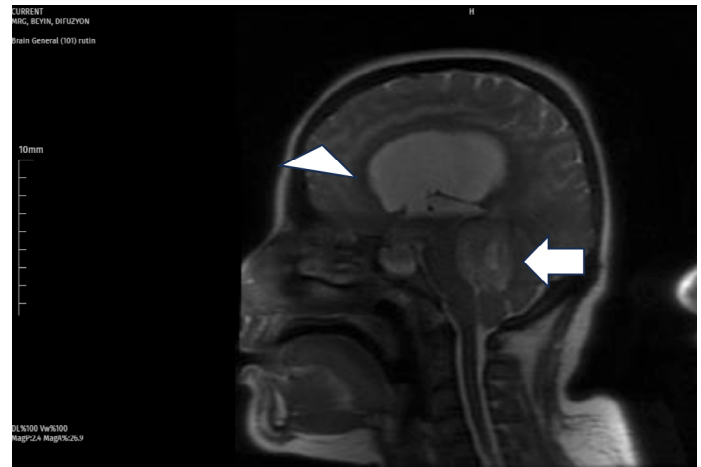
Coronal plane of brain magnetic resonance imaging. Lateral ventricles show dilation (arrowhead). The mass compresses the cerebellum, brainstem, and ventricles (arrow).
